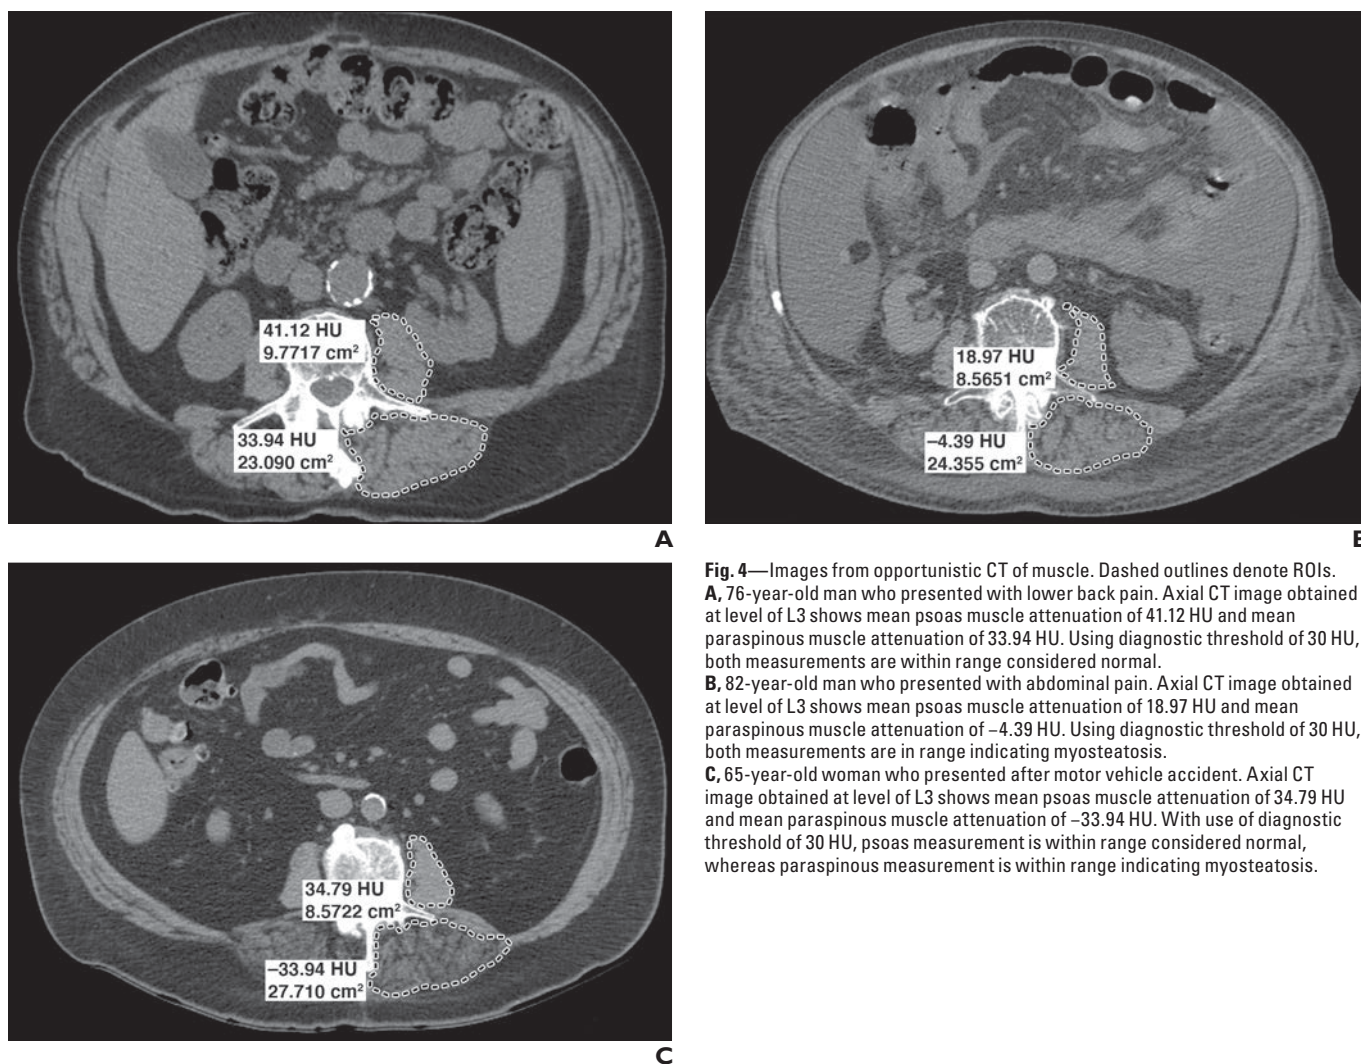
Images from opportunistic CT of muscle. Dashed outlines denote ROIs. A, 76-year-old man who presented with lower back pain. Axial CT image obtained at level of L3 shows mean psoas muscle attenuation of 41.12 HU and mean paraspinous muscle attenuation of 33.94 HU. Using diagnostic threshold of 30 HU, both measurements are within range considered normal. B, 82-year-old man who presented with abdominal pain. Axial CT image obtained at level of L3 shows mean psoas muscle attenuation of 18.97 HU and mean paraspinous muscle attenuation of -4.39 HU. Using diagnostic threshold of 30 HU, both measurements are in range indicating myosteatosis. C, 65-year-old woman who presented after motor vehicle accident. Axial CT image obtained at level of L3 shows mean psoas muscle attenuation of 34.79 HU and mean paraspinous muscle attenuation of -33.94 HU. With use of diagnostic threshold of 30 HU, psoas measurement is within range considered normal, whereas paraspinous measurement is within range indicating myosteatosis.
